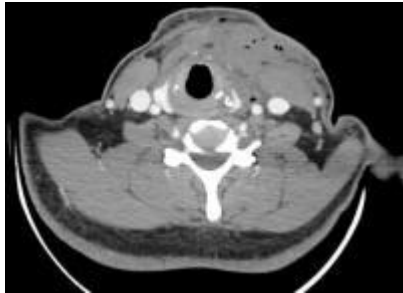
CT scan neck - Axial section : Soft tissue swelling with subcutaneous haematoma is noted in neck along with subcutaneous emphysema involving pre-laryngeal, pre and para-tracheal space. No evidence of any arterial or venous injury. No evidence of contrast extravasation. No evidence of fracture. No evidence of tracheal compression
